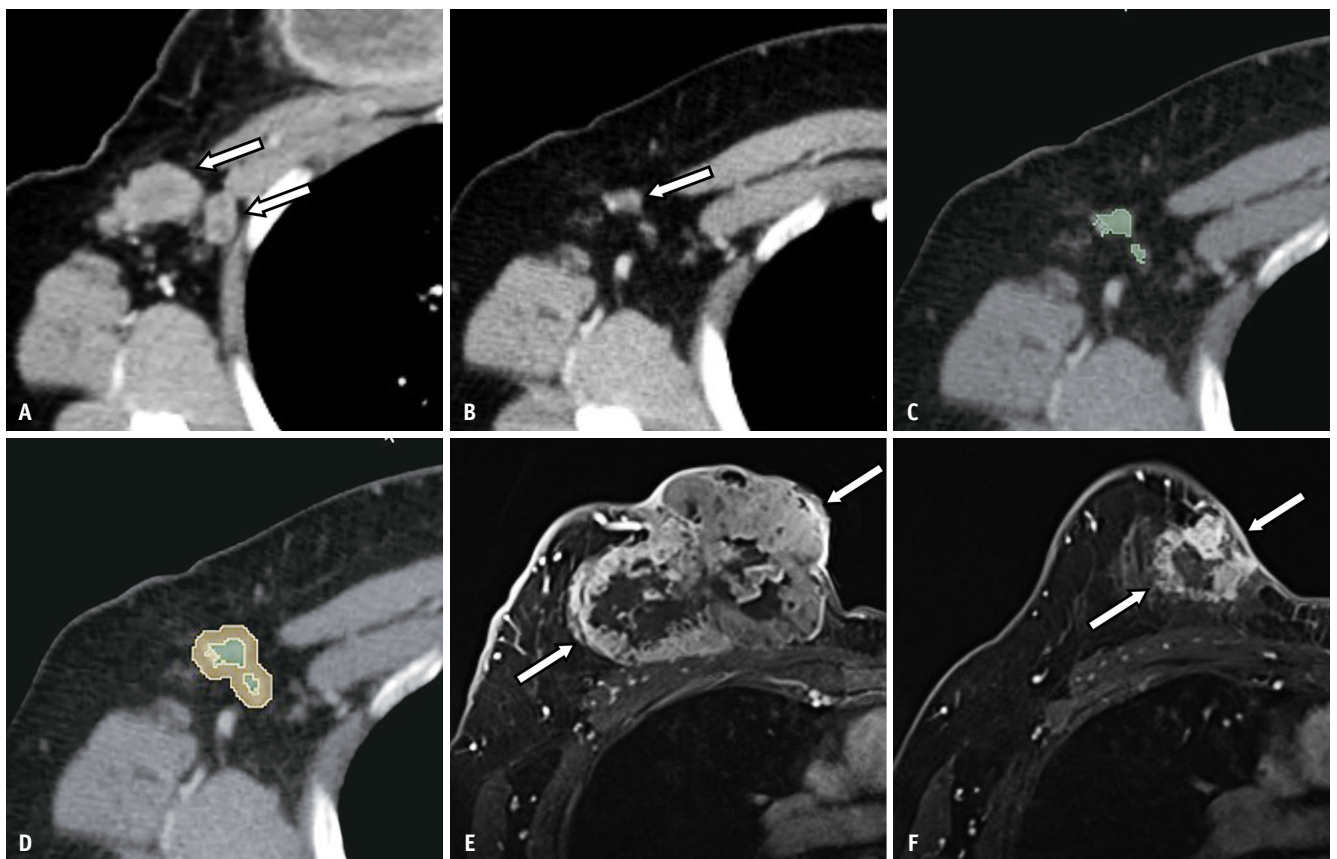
Example of residual axillary nodal metastasis and lymph node segmentation. The pre-neoadjuvant chemotherapy (NAC) axial contrast-enhanced computed tomography (CT) image of a 48-year-old woman shows two metastatic lymph nodes (arrows in A) at the level I right axillary lymph node. The lymph nodes show heterogeneous enhancement and cortical irregularity, and the short-axis diameter of the largest node is 30 mm. The post-NAC CT image shows a decrease in the size of the lymph nodes with remaining heterogeneous enhancement and cortical irregularity (arrow in B). Green and yellow in (C) and (D) represent the intranodal and perinodal regions of interest in post-NAC CT images, respectively. The post-NAC magnetic resonance imaging (MRI) image (F) shows that the primary breast cancer decreased in size compared to that in the pre-NAC MRI image (E) but remained in the right breast (arrows in E and F). The final pathologic result after axillary surgery revealed residual nodal metastasis.
